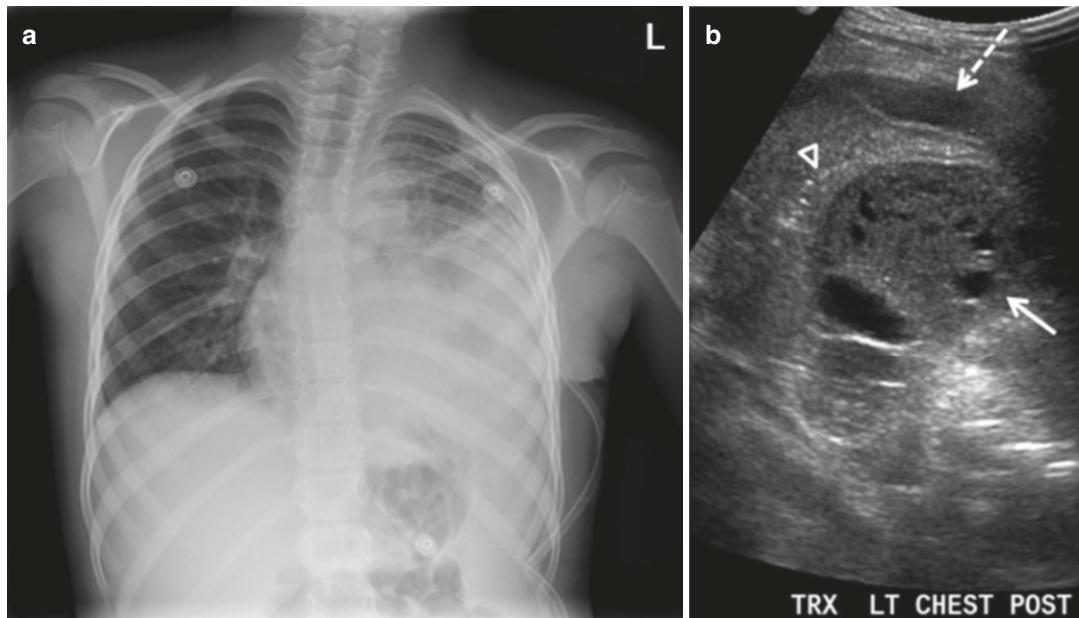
(a) Frontal chest radiograph of 6-year-old girl admitted for pneumonia, showing a large left-sided consolidation and pleural effusion with focal lucency within the opacity. (b) Ultrasound of the left chest shows hypoechoic lung, with areas of liquefaction representing a focal area of necrotizing pneumonia (solid arrow), adjacent
